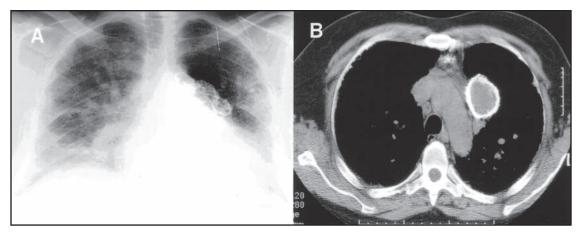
A,* chest radiograph from a patient with silicosis showing left hilar adenopathy with egg-shell calcification. *B,* chest CT scan demonstrating egg-shell calcification.
